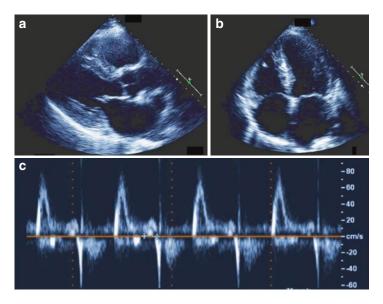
TTE. (a) Parasternal long axis view. LV EF of 30%, global hypokinesis, increased wall thickness (IVSd of 1.5 cm, LVPWd 1.5 cm, LVIDd 4.3 cm), moderately dilated right ventricle (RV), increased RV wall thickness, moderately reduced RV systolic function, no pericardial effusion. (b) Apical 4-chamber view. Biatrial enlargement (Left atrial (LA) volume of 78.6 ml, LA volume index of 42.8 ml/m²), mild mitral regurgitation, mild tricuspid regurgitation, no LV thrombus. (c) Mitral Inflow Wave Pattern by Pulsed-wave Doppler. Mitral valve (MV) E wave velocity of 81.4 cm/s, MV A velocity of 22.5 cm/s and E/A ratio of 3.6; LV IVRT of 0.10 s (not shown, Med E' velocity 2.65 cm/s, Med E/E' 30.7, Lat E' velocity 4.13 cm/s, Lat E/e' 19.7). *IVSd* interventricular septal thickness at diastole, *LVPWd* left ventricular posterior wall thickness at diastole, *LVIDd* left ventricular diameter at diastole, *IVRT isovolumic relaxation time*
